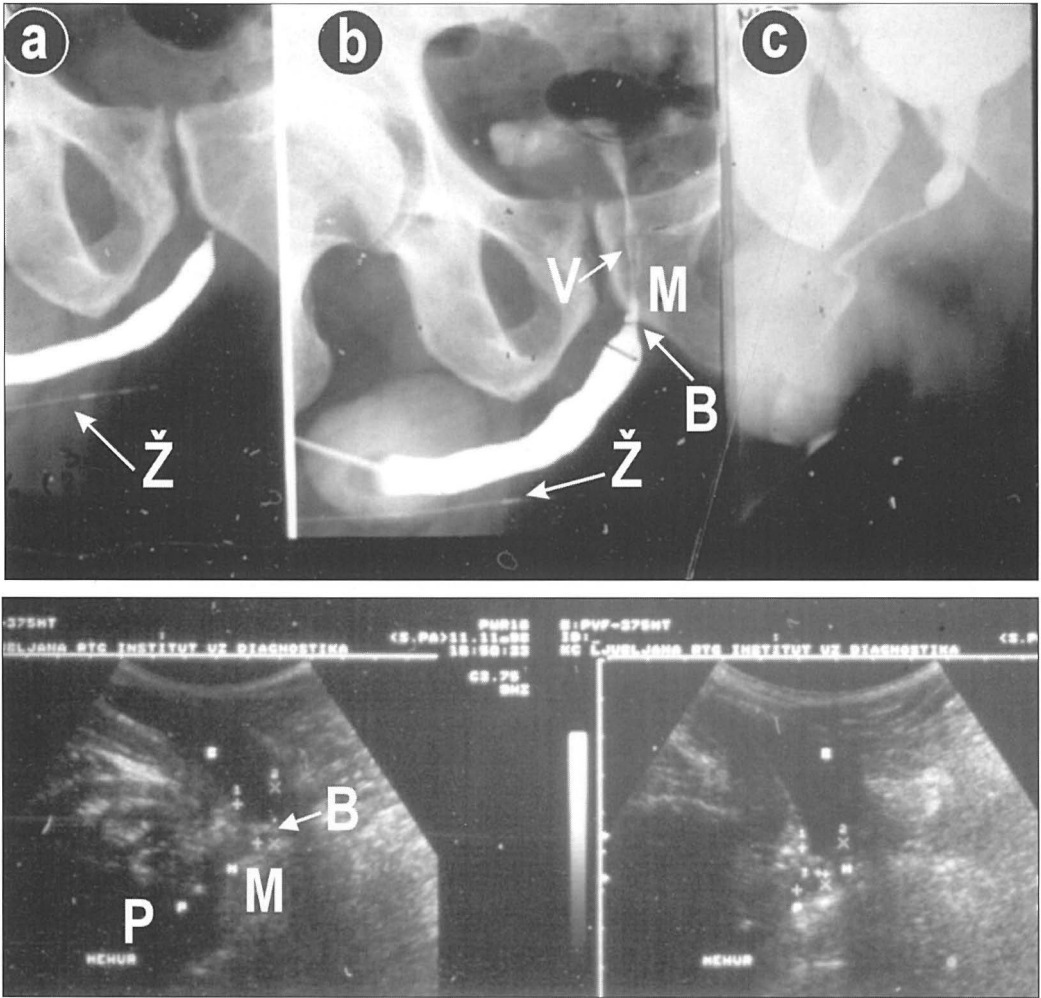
Evaluation of bulbar stricture (B) with suspected extension to membranous part (M) near prostatic portion (P) by radiography (a,b,c) and sonography.
